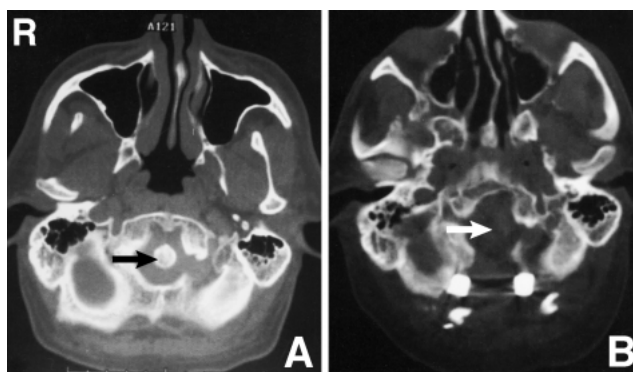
Case 1. Axial bone window computed tomography scans (A) before (arrow) and (B) after odontoidectomy (arrow).
